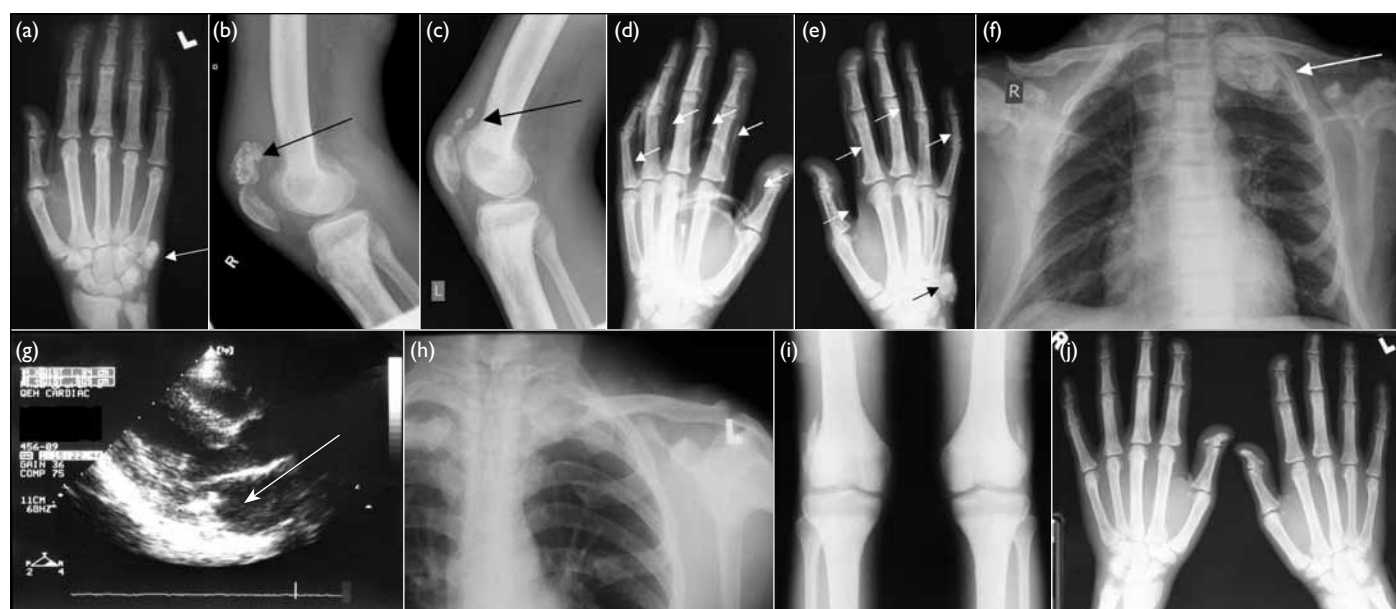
(a) An X-ray of left hand taken on first admission showed extraosseous calcification over left wrist (white arrow) with resorption of distal tufts of left thumb and fingers. Diffuse osteosclerosis was also noted. (b) The lateral view of right knee with calcification over suprapatellar region (black arrow). (c) The lateral view of left knee with calcification along the prepatellar tendon (black arrow). Oblique views of (d) left and (e) right hands with periarticular calcification over right wrist (black arrow). Apart from the calcification over left wrist, linear calcifications along the digital vessels were seen (white arrows). (f) A chest X-ray shows abnormal subcutaneous calcification and a large tumoural calcinosis over left sternoclavicular junction (white arrow). The lung field was congested. (g) Echocardiogram (parasternal long axis view) shows an echo-dense mass (white arrow) measuring 2 x 1.4 cm at mid-posterior left ventricular wall. (h, i, j) Resolving calcification over chest X-ray; the linear vascular calcifications over both hands and tumoural calcification over left wrist had resolved and disappeared 1 year after parathyroidectomy. Some abnormal calcification is still observed at periarticular region of both knees
